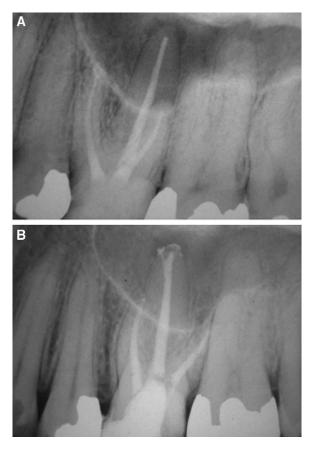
(*A*) Preoperative radiograph of retreatment of maxillary first molar. (Courtesy Kevin Edwards, DDS, Portland, Oregon) (*B*) Postoperative radiograph.
